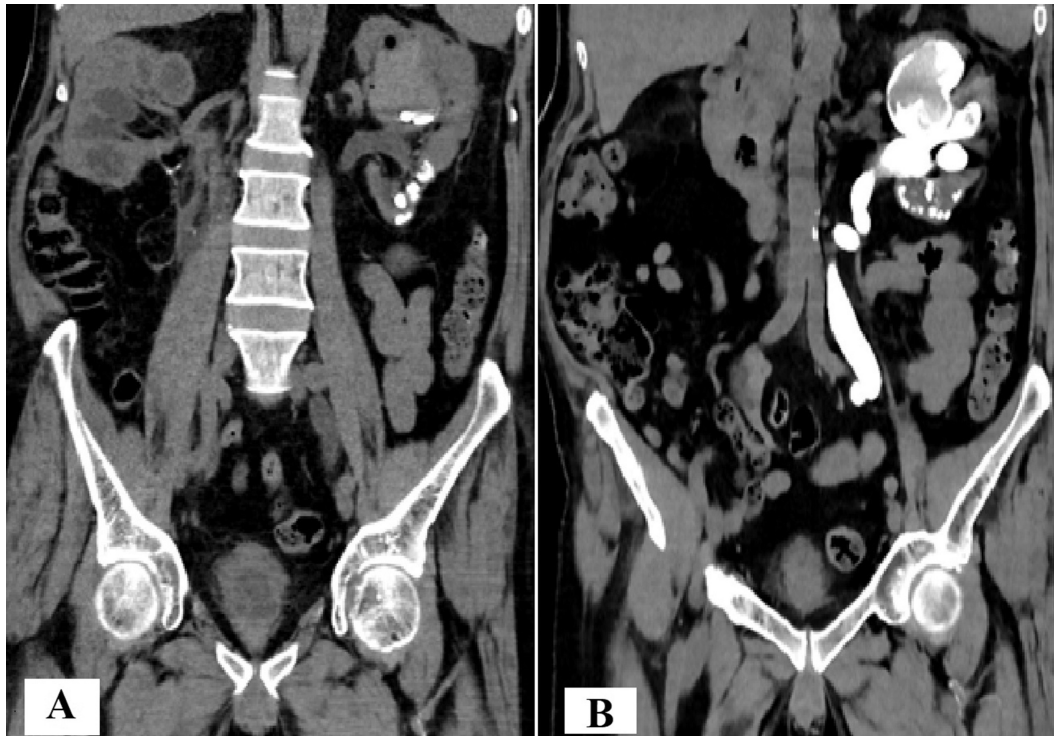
CT abdomen and pelvis: Rapid grower *M Fortuitum/chelonae* complex. (A) NCCT. (B) Left antegrade pyelogram.
